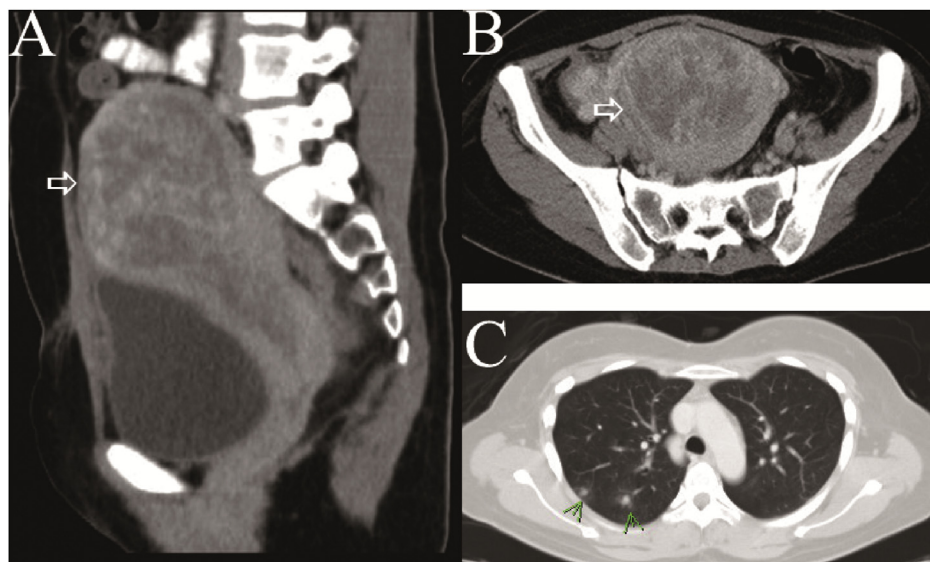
Computed tomography revealed (A, B) a heterogenous mass lesion measuring 16 cm × 12 cm × 9 cm in the uterine cavity and (C) multiple small nodules in lung fields.
